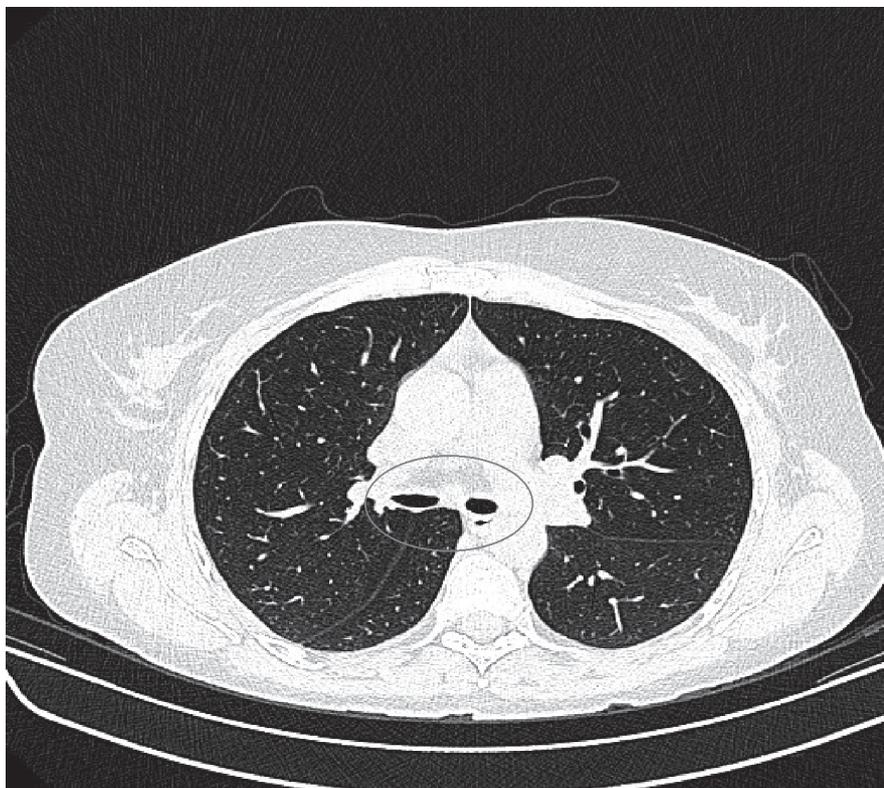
CT Thorax showing collapsing bronchi with small caliber (encircled).
